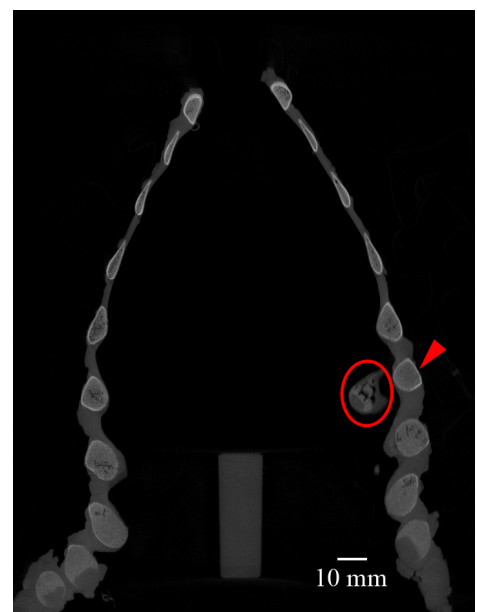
Coronal plane CT slice of Fig 2 taken through posterior of ribs subsequent to abusive scenario mechanical test. See text for annotation detail.
